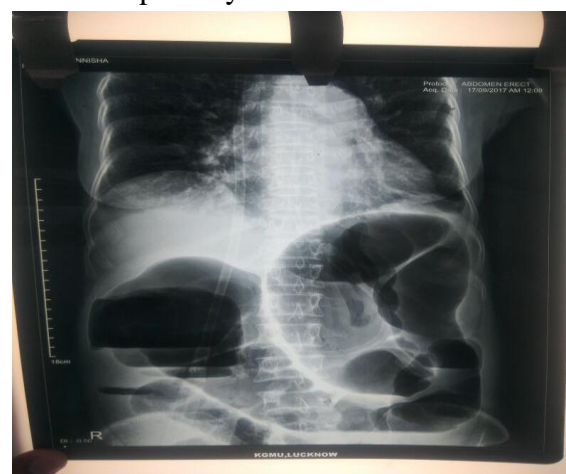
Preoperative plain X-ray abdomen AP erect view revealing a twisted loop of colon
